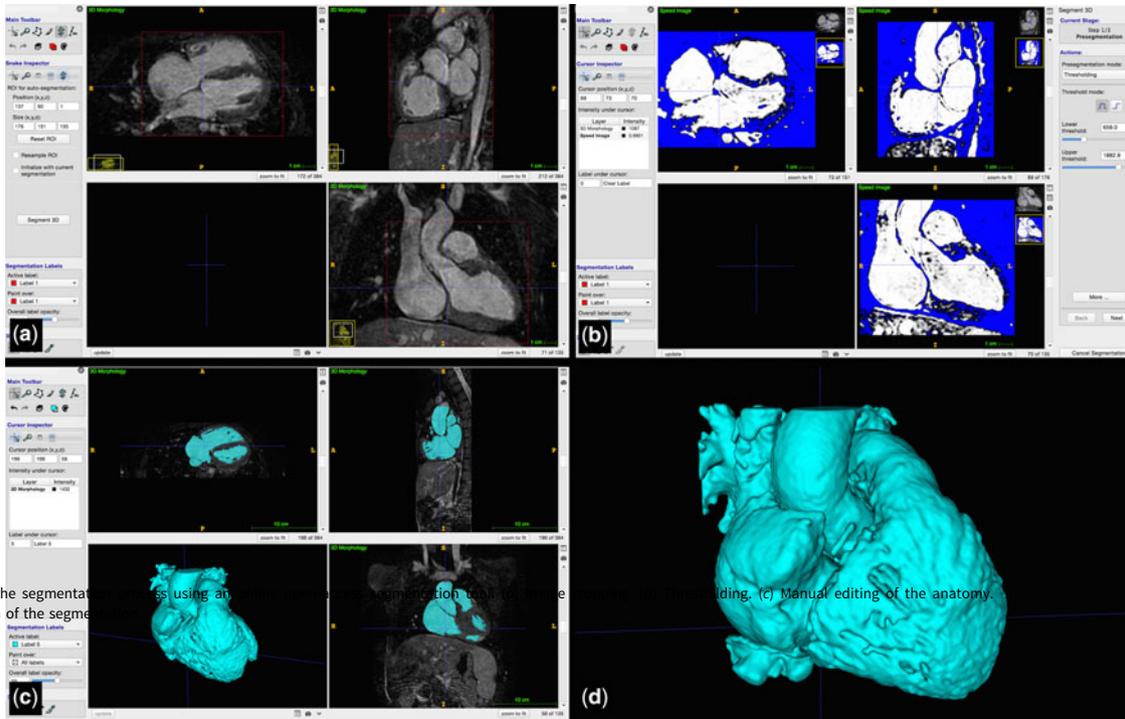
Steps of the segmentation process using an automatic segmentation tool. (a) Initial MRI slices. (b) Segmented MRI slices. (c) Manual editing of the anatomy. (d) 3D representation of the segmented anatomy.
